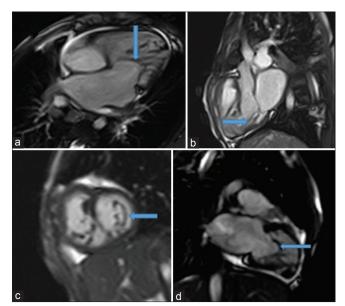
Cardiac magnetic resonance imaging – four-chamber (a) and three-chamber (b) steady-state free precession images demonstrate the elongated, mildly thickened anterior and posterior mitral valve leaflet with absent chordae. Short-axis oblique (c) and two-chamber (d) images demonstrate the fibrous band between the anterolateral and posteromedial papillary muscles. (c) Hammock-like appearance with two leaflets between the papillary muscles
